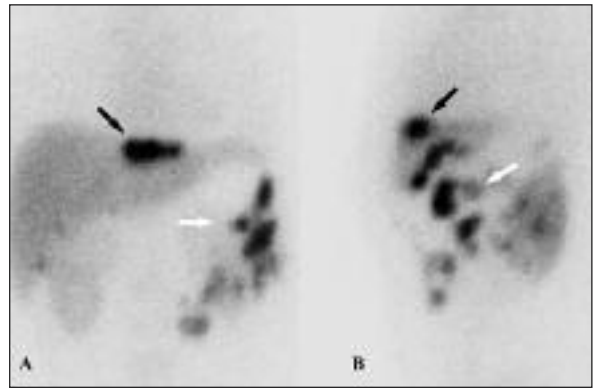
Anterior (A) and left lateral (B) images of the heat denatured red blood cell (RBC) scintigraphy demonstrate multiple focal areas of radiotracer uptake around the splenic bed (white arrow) and upper part of the liver parallel to the contour of the diaphragm (black arrow) consistent with the diagnosis of splenosis.
